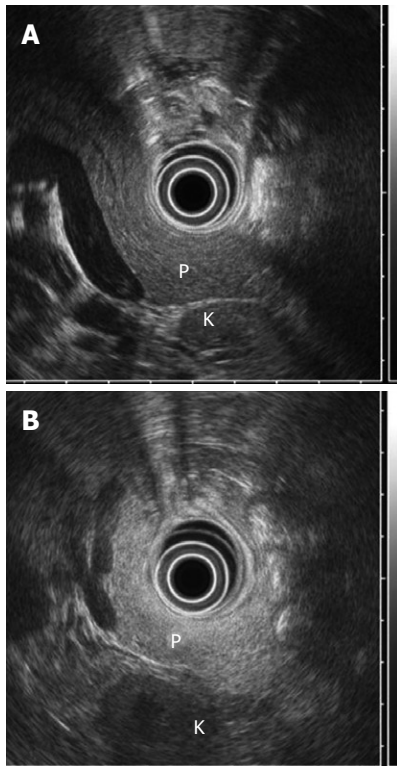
Echogenicity of the pancreas on endoscopic ultrasound. A: Normal echogenic pancreas; B: Hyperechogenic pancreas compared to kidney. P: Pancreas; K: Kidney.
